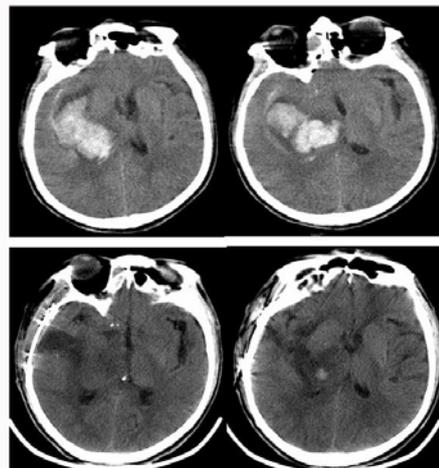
Pre-Operative CT scans (Above) of Case VI (62 years/male) found right intracranial hemorrhage with a midline shift. The hyper dense (bright) area represents acute bleeding. There is a midline shift to the patient's left. Post-operative CT scans (Below) of Case I (62 years/male) showing evacuation of hematoma.
